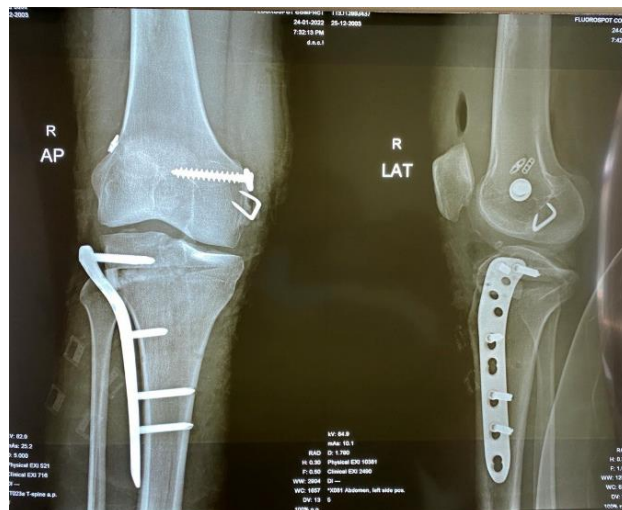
Anteroposterior and Lateral Radiograph after ACL reconstruction and Varus Osteotomy
